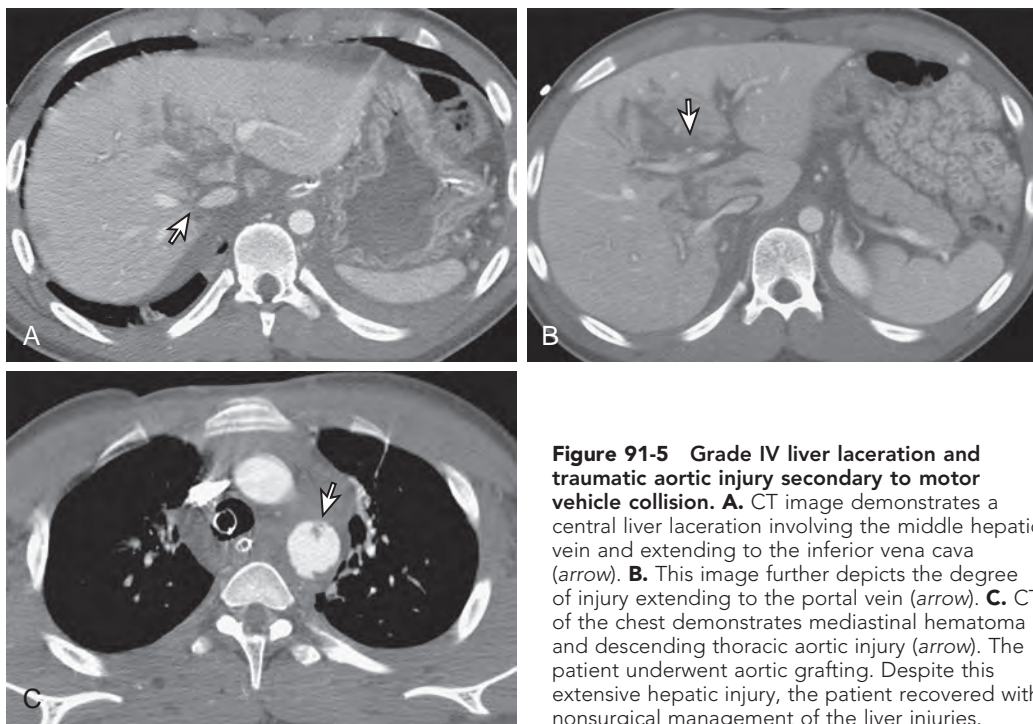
Grade IV liver laceration and traumatic aortic injury secondary to motor vehicle collision. A. CT image demonstrates a central liver laceration involving the middle hepatic vein and extending to the inferior vena cava (arrow). B. This image further depicts the degree of injury extending to the portal vein (arrow). C. CT of the chest demonstrates mediastinal hematoma and descending thoracic aortic injury (arrow). The patient underwent aortic grafting. Despite this extensive hepatic injury, the patient recovered with nonsurgical management of the liver injuries.
